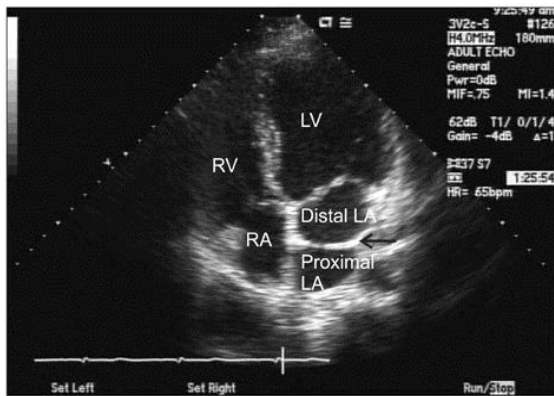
Transthoracic echocardiogram (apical 4-chamber view). NB: LA = Left Atrium. LV = Left Ventricle. RA = Right Atrium.
